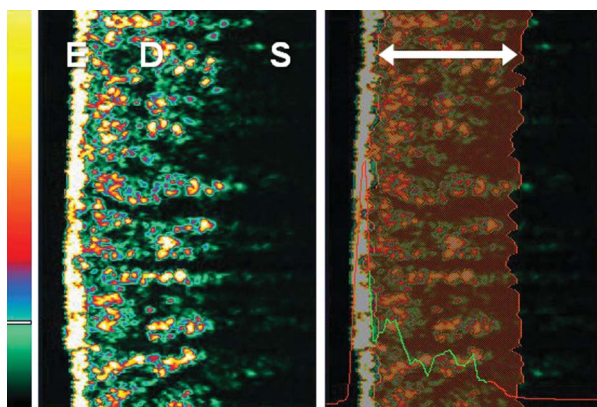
Representative ultrasonographic images from a 44-year-old woman. The intensity of reflected echoes is visualized as a color scale: white > yellow > red > blue > green > black. E = epidermal entry echo; D = dermis; S = subcutis. Double-headed arrow represents the area designated as the dermis. In these images, dermal thickness is 1.74 mm and dermal echogenicity is 33.1%.
